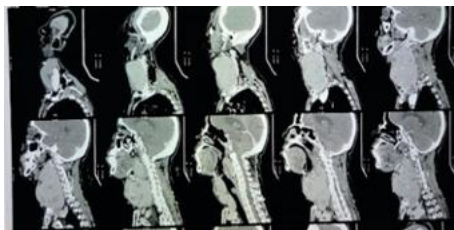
CT Neck Demonstrating Scabbard Trachea with Marked Luminal Narrowing.
